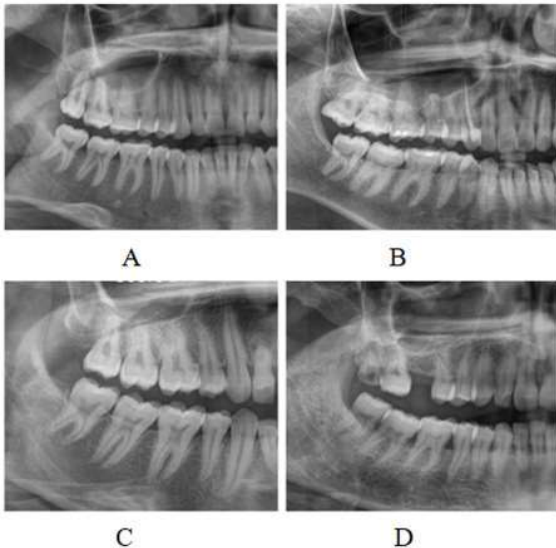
The radiographic visibility in lower third molars is displayed by the OPG as follows: (A) Stage 0 (B) Stage 1 (C) Stage 2 (D) Stage 3.
